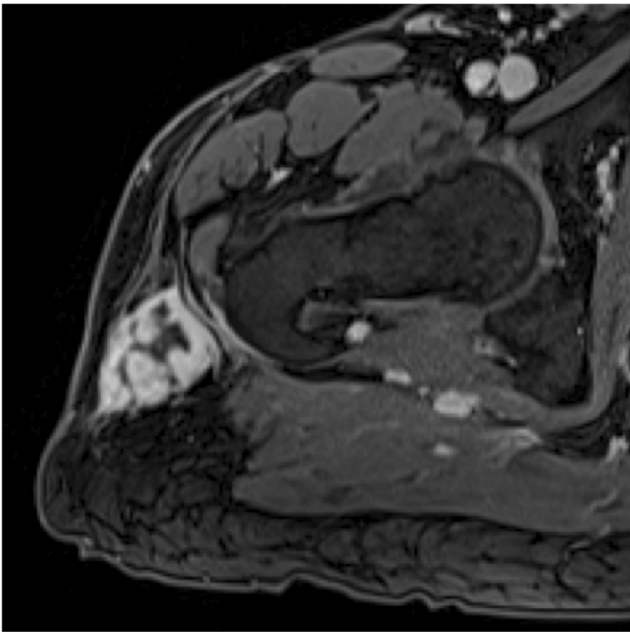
a Axial T1W FSE MR image. b Coronal STIR MR image
